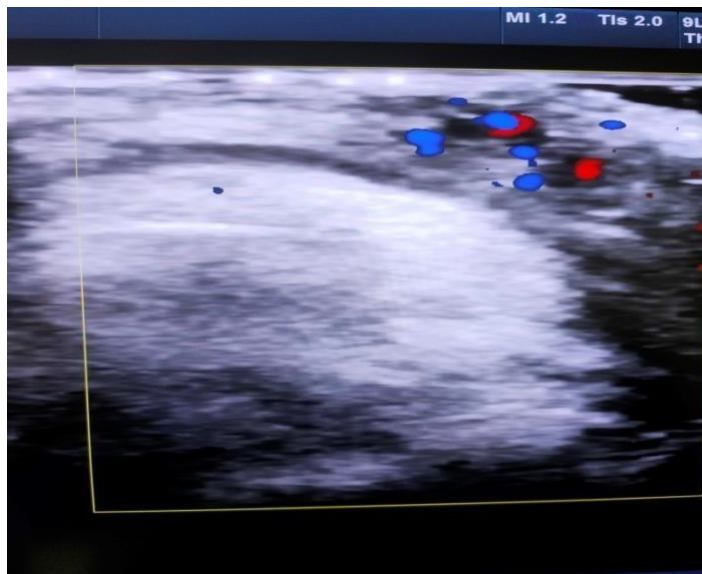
Doppler US image showing low flow hemangioma in lower lip
